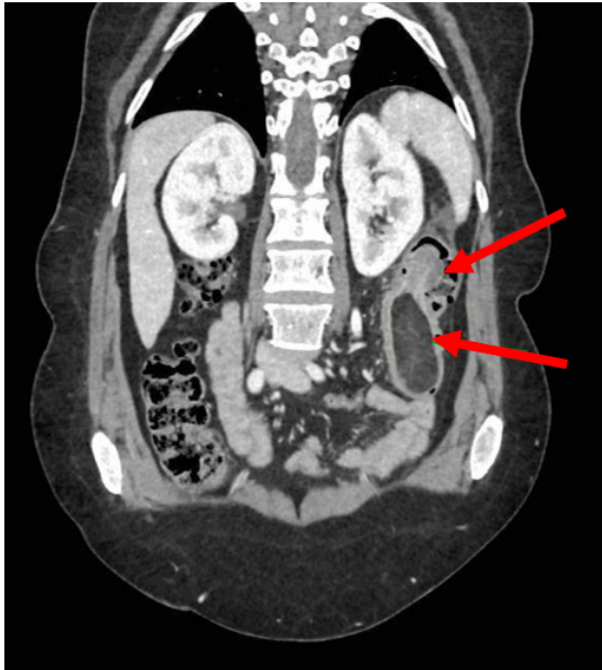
Abdominal CT scan (coronal section) with findings of colonic intussusception.
